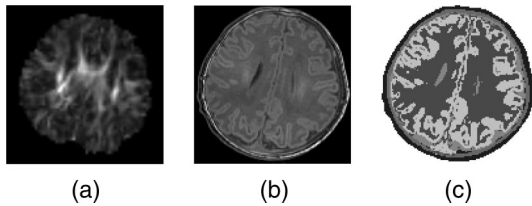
Slices of DT and T1 data along with the segmentation of the T1 data. (a) FA index calculated from the DT data. (b) T1-weighted anatomical MR image. (c) Segmentation of the T1-weighted image.
